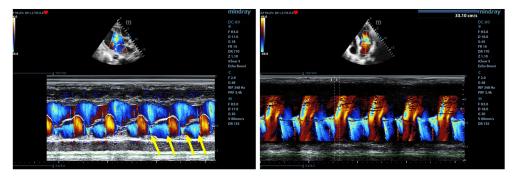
a.4. M-color flow Doppler showing the blood flow during cardiac cycles in two cases with dilated cardiomyopathy (left: holosystolic mitral regurgitation flow accentuated in proto- and mezosystole (arrows); parasternal long axis; right: decreased propagation velocity of the diastolic mitral flow (Vp=33.1 cm/s) and holosystolic mitral regurgitation; 4-chambers view)
